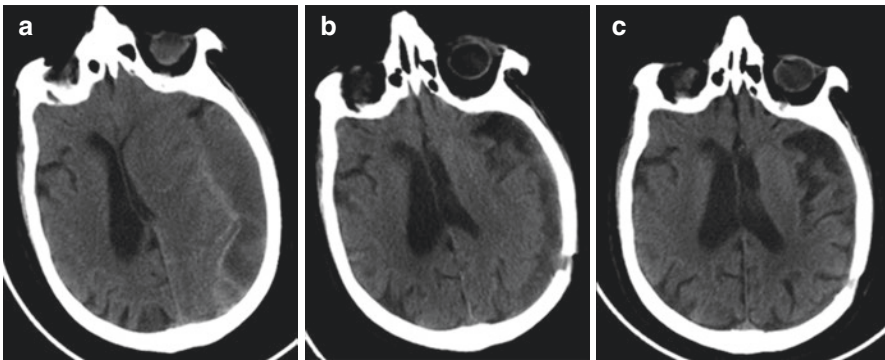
(a) Initial brain CT scan demonstrating left compressive CSDH in elderly patient. (b) One-month follow-up CT scan demonstrating significant reduction of the CSDH and the related mass effect on the midline structures. (c) Four-month follow-up CT scan demonstrating total absence of the CSDH
